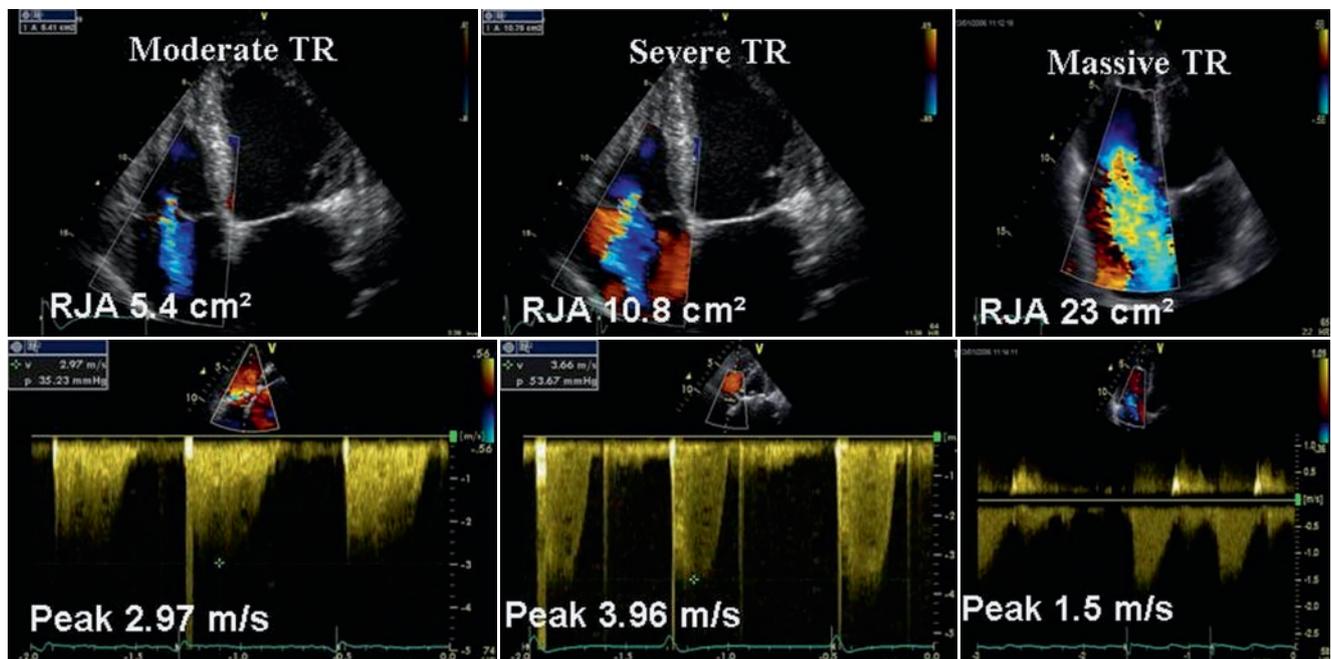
Three examples of various degrees of TR, mild (left), moderate (middle), and severe (right) are provided. The RJA increases with the severity of TR. The peak velocity of TR (CW Doppler) allows
